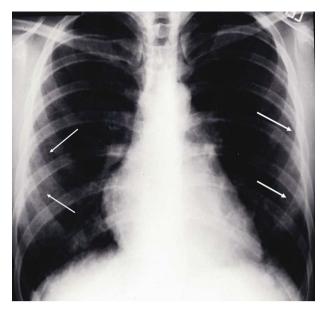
Chest x-ray showing bilateral infiltrates, in the mid and lower lung zones (arrows).
